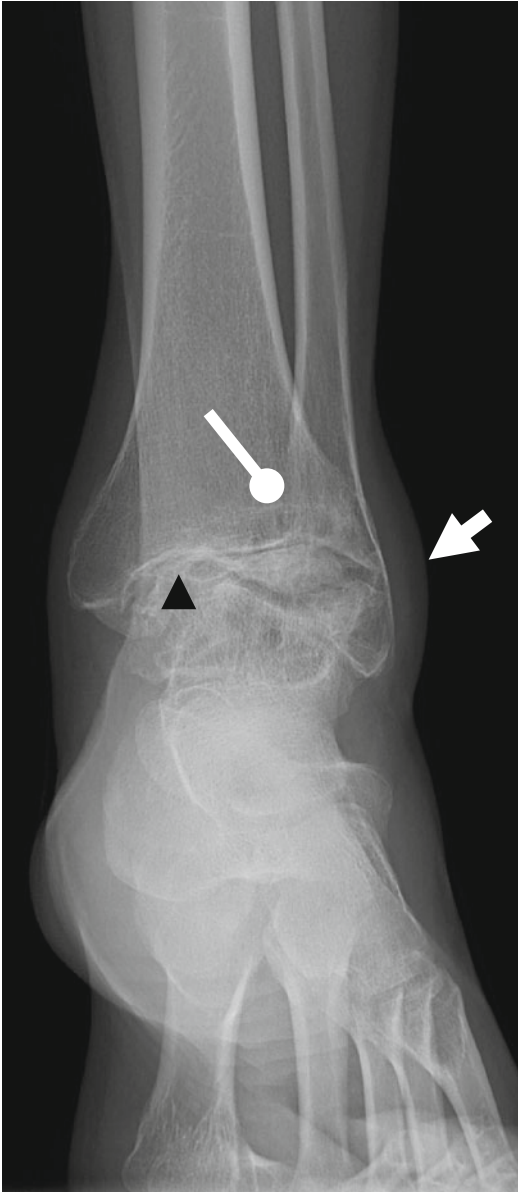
X-ray anteroposterior (AP) view of the ankle demonstrating soft tissue swelling (*arrow*), osteoporosis, epiphyseal overgrowth, subchondral bone cyst (*round arrow*) with significantly narrowed joint space (*arrowhead*)
